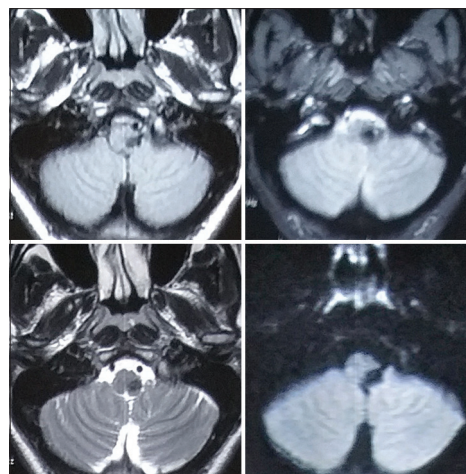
Magnetic resonance imaging of the brain - showing tumor
